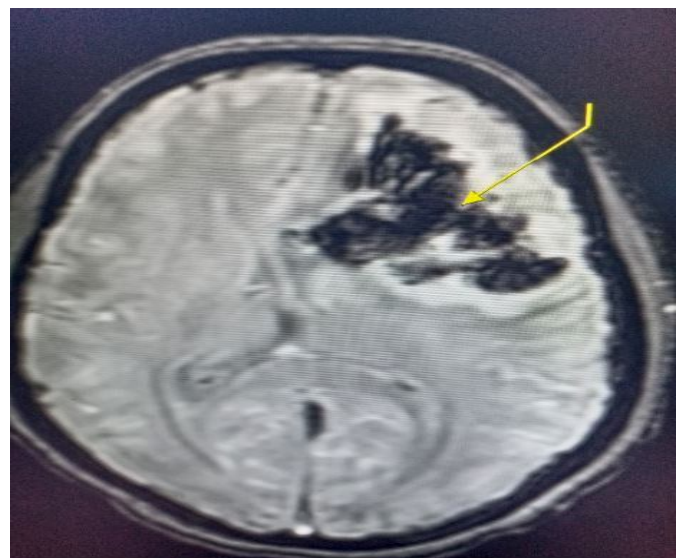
Magnetic resonance imaging (MRI) in axial view showing a left frontal bleed with mass effect and midline shift (arrow pointed)
